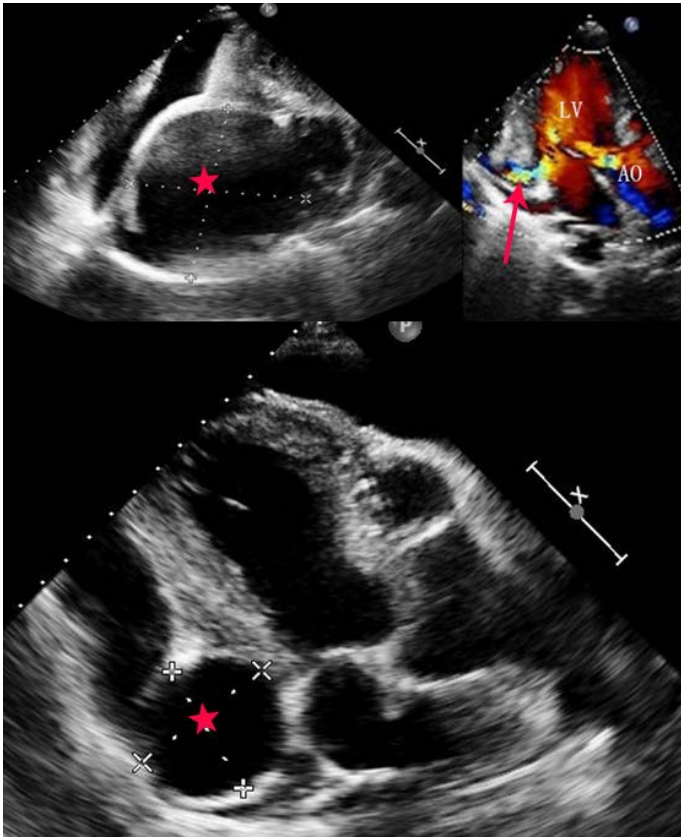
Echocardiography showed aneurysms (star) of RCA with flow to LV (arrow).
